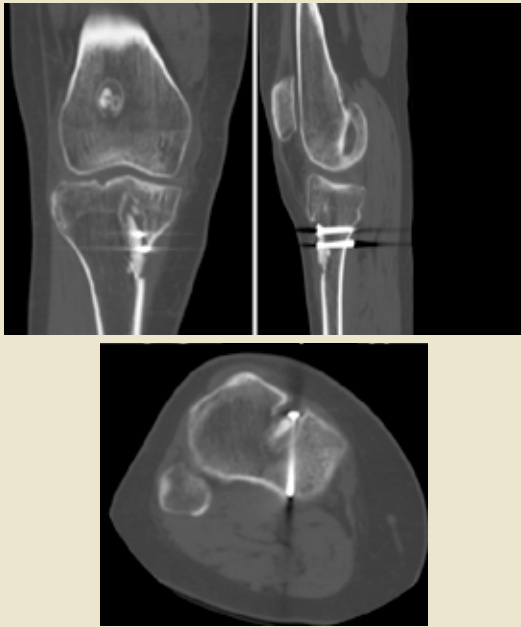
Coronal, sagittal, and axial CT images 7 months after right knee revision ACL reconstruction using screw fixation of the graft within the tibial tunnel.
